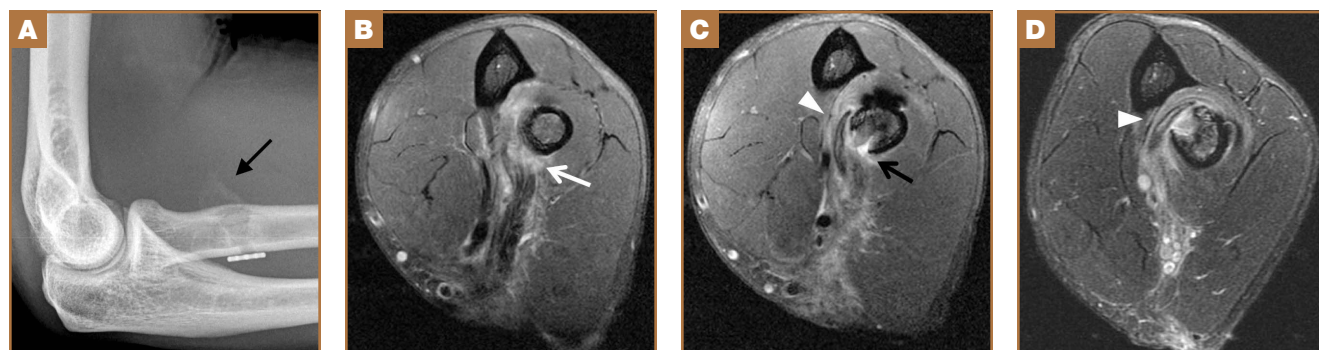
Imaging shortly after surgery. (A) Seven weeks after surgery, lateral radiograph shows expected location of Endobutton (Arthrex, Naples, Florida) and early heterotopic bone formation (arrow). (B,C) Nine weeks after surgery, axial T2-weighted magnetic resonance imaging (MRI) in flexed, abducted, and supinated position shows high-grade partial-thickness tear of biceps tendon with retracted fibers (white arrow), focal kink and fluid at torn distal tendon (black arrow), and heterotopic piece of bone (arrowhead). (D) Axial T2-weighted MRI in extended and pronated position at essentially same level and plane as (B) shows piece of bone (arrowhead) entering and partially occupying radioulnar space, acting as “trapdoor” to impinge on tendon.
